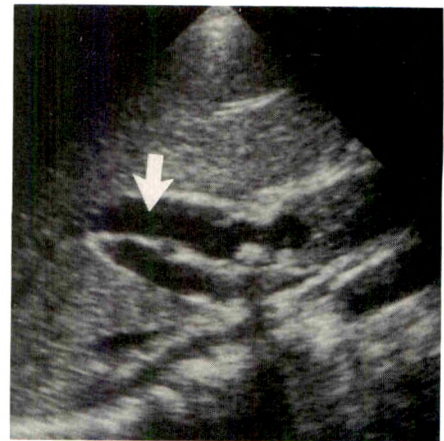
Sickle cell disease with choledocholithiasis. Oblique sonogram with child supine shows dilated common bile duct (arrow) with at least one stone creating a shadow in distal portion.
